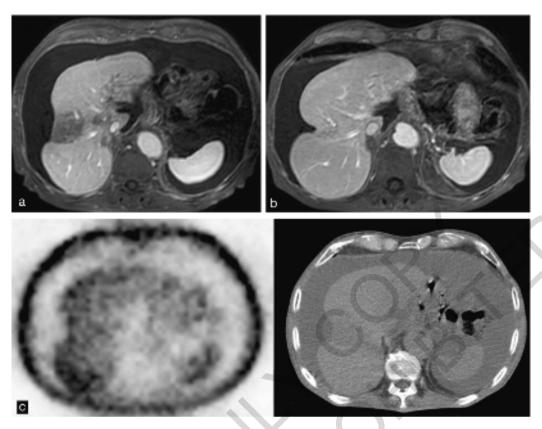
Venous-phase enhanced follow-up MRI sequences show progressive reduction of the infarction size, with hepatic atrophy, capsular retraction and hypertrophy of the remaining parenchyma, on March 2019 (A) and November 2019 (B); CT-PET scan, on June 2019, did not show any pathological uptake (C)
